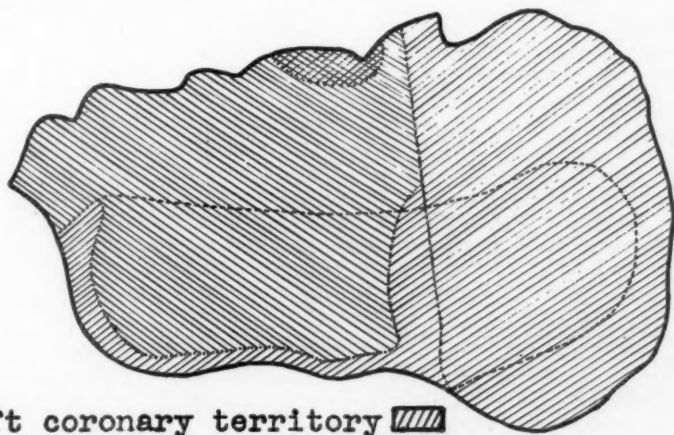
Anterior aspect of the heart injected and radiographed.
